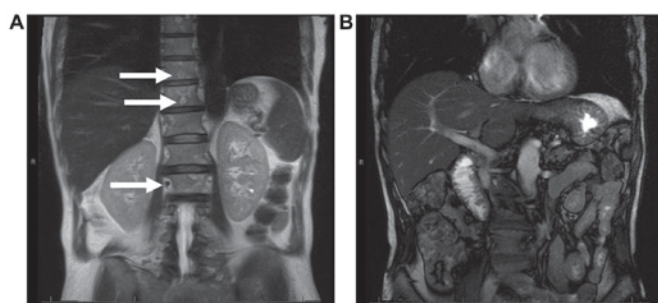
MRI of Abdomen demonstrating (A) diffuse skeletal metastasis, (B) normal liver without evidence of biliary obstruction.
